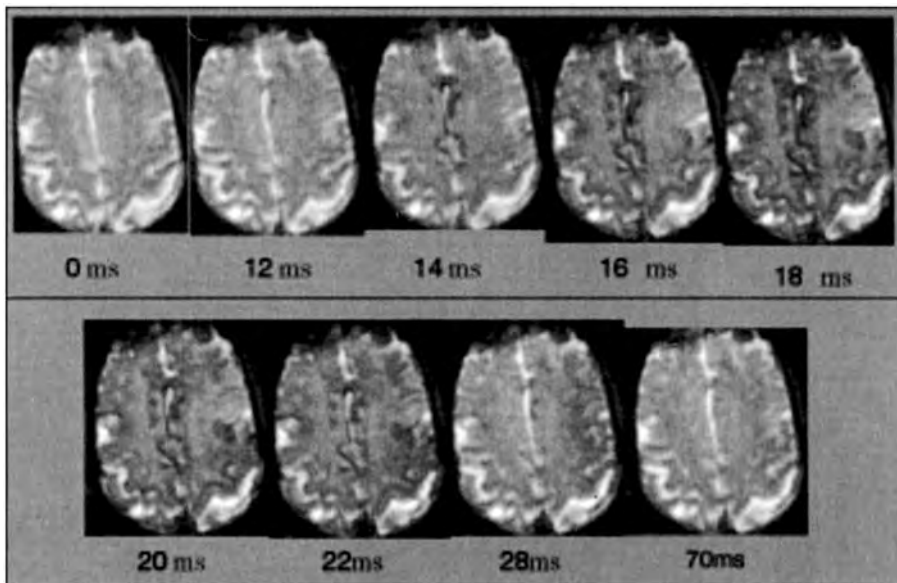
Perfusion weighted contrast MR image showing an area of under perfusion in the left frontal lobe.
